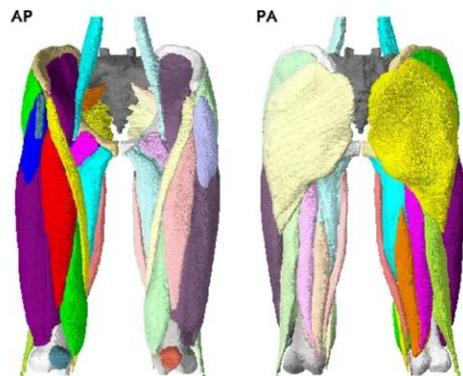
Three-dimensional models reconstructed from computed tomography images
